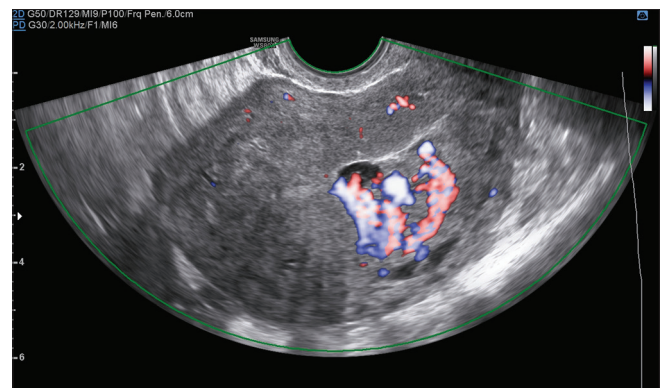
Color mosaic pattern of the myometrium analyzed with High Definition Power Doppler
